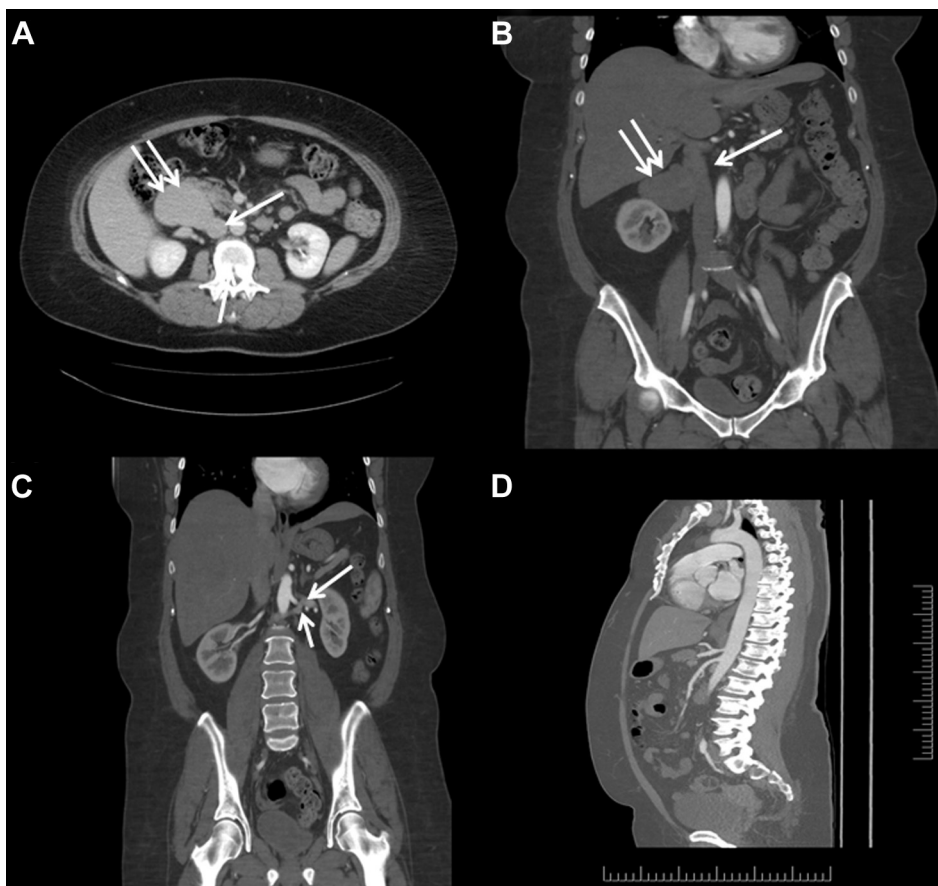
Abdominal computed tomography (CT) scan (venous phase) in (A) axial and (B) coronal views demonstrates a sacular inferior vena cava (IVC) aneurysm (IVCA). The *single arrow* points to the IVC and the *double arrow* points to the IVCA. The images show (C) the circumaortic left renal vein (CLRV) between the two *single arrows* and (D) a sagittal section of the thoracoabdominal aorta with no dissection.
